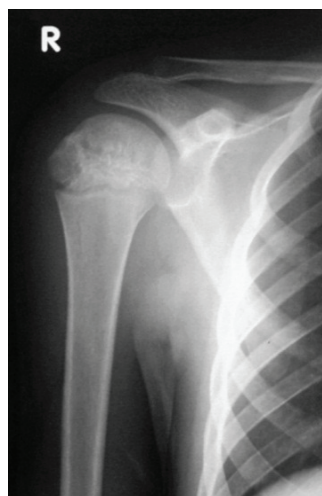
Anteroposterior radiograph of the right shoulder showing a well-defined lytic epiphyseal lesion.
